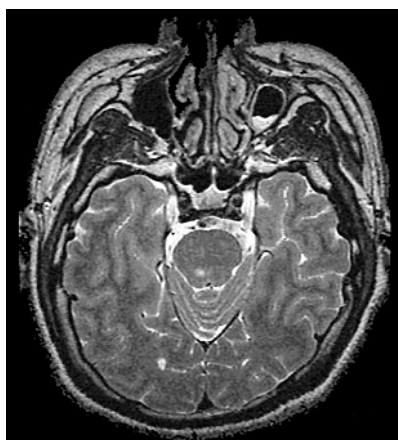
Brain magnetic resonance imaging: an axial T2 weighted image showing a right paramedian infarct of lacuna size situated in the tegmentum of the most rostral pons.
